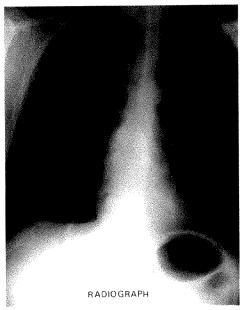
Radiograph suitable for use in Digital Radiography.
